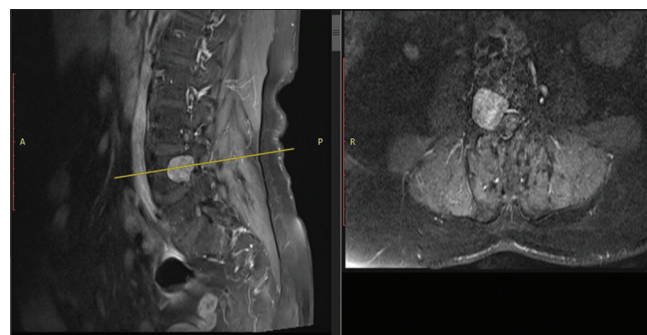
Lumbar magnetic resonance imaging of a 70-year-old female patient who experienced low back and right leg pain for 5 months. Contrast-enhanced T1-weighted image showed a well-circumscribed lesion which eroded right pedicle of L4 vertebra and measuring 27 mm × 28 mm × 16 mm, narrowed right L4 foramen, and showed heterogeneous enhancement after contrast substance on both of T1 and T2. She underwent operation and neurosurgeons distinguished that the lesion was intradural extramedullary intraoperatively. Gross-total resection had performed. The lesion was confirmed to be a schwannoma. The patient's pain relived and she was intact neurologically. On her postoperative 5th year control visit. Left side: Sagittal contrast-enhanced T1-weighted image; Right side: Axial contrast-enhanced T1-weighted image. Note the lesion showed moderate homogeneous enhancement, because of its location and eroded in the pedicle, and bony cancer was suggested, but schwannoma was considered in differential diagnosis
